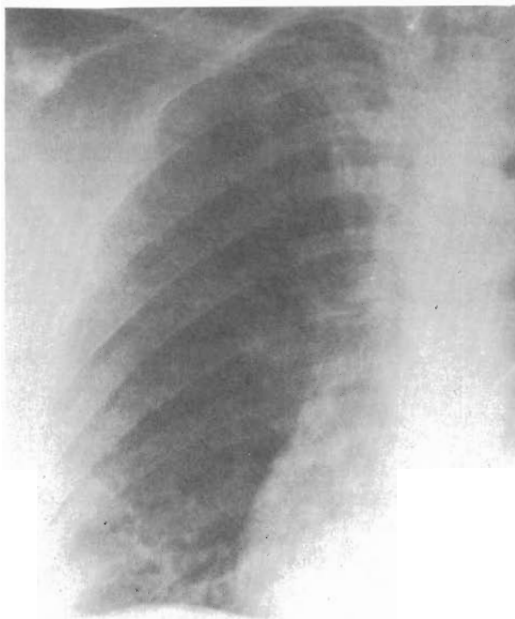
Chest x-ray film of same patient as Figure 1 showing that withdrawal of catheter has elevated and tightened knot.
